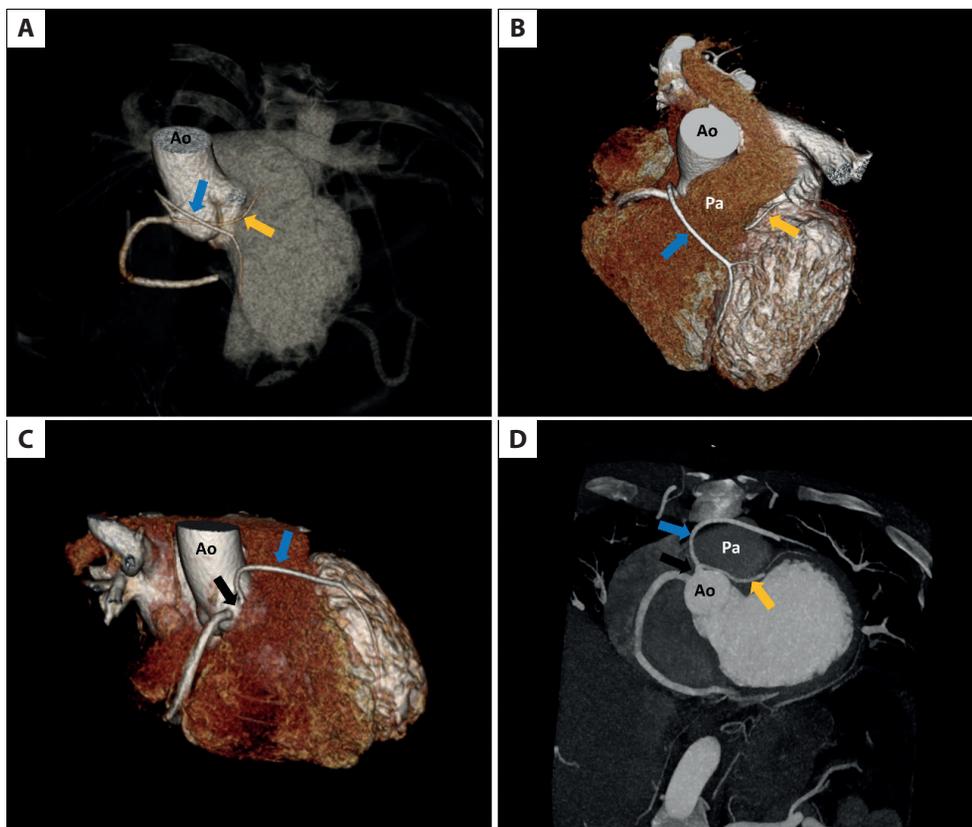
Three-dimensional computed tomography reconstruction (A–C) and MIP (D) images showing an anomalous origin of the left main artery from the right coronary sinus (black arrow), and prepulmonic course of the LAD (blue arrow) and subpulmonic course of the LCx (orange arrow)
